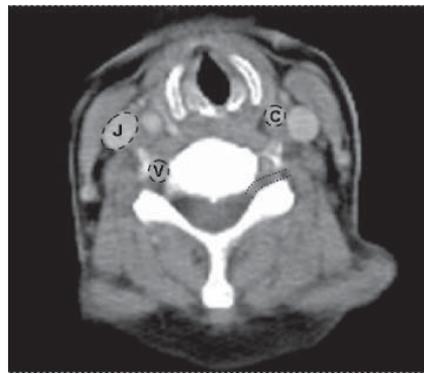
Contrast enhanced axial CT image through a cervical vertebra. This figure demonstrates the relationship of jugular vein (J), carotid (C) and vertebral (V) arteries, and the exiting cervical nerve root (interrupted parallel lines). Hence, demonstrating the potential hazards encountered during needle entry.
